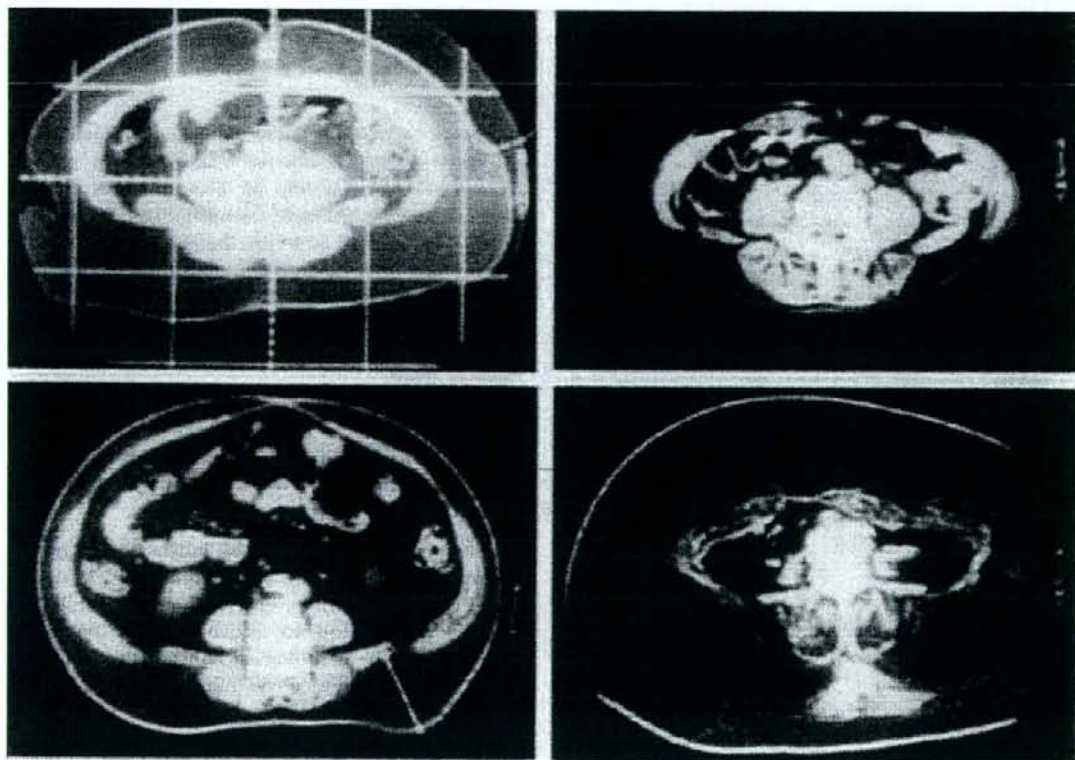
CT scanning images of obese subjects. Note the huge amount of subcutaneous fat in the lower right panel (D). Note also the relatively small amount of subcutaneous fat but massive intra-abdominal visceral fat in the lower left panel (C).
